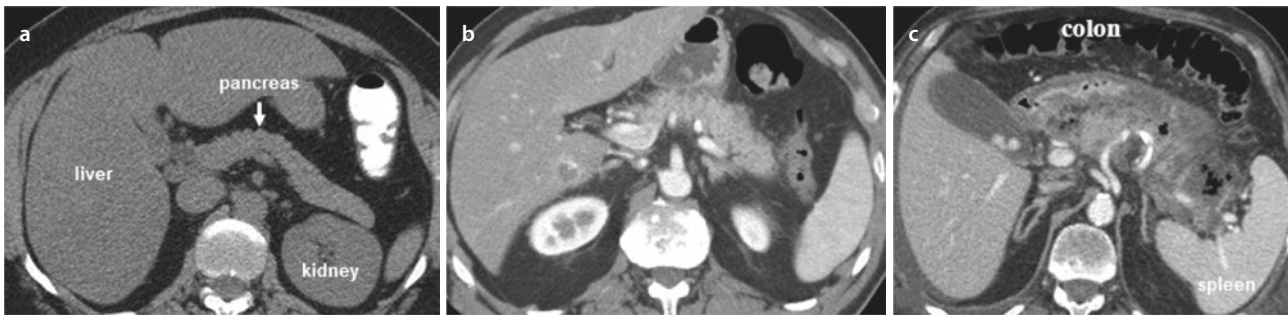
CT scan of the abdomen and pancreatitis. a Normal pancreas. b Mild pancreatitis: edema of the gland and surrounding tissues; the pancreas is well perfused by the intravenous dye administered. c Severe pancreatitis: the pancreas is very edematous and necrotic with perfusion defects and air bubbles indicating abscesses
